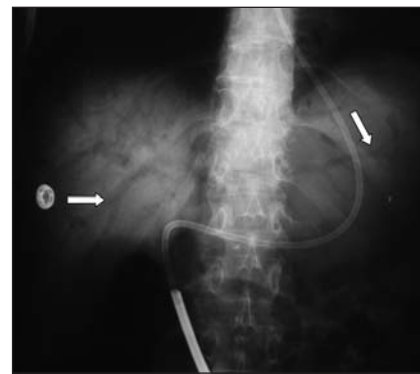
Plain film radiograph showing air in the portomesenteric circulation (arrows).
